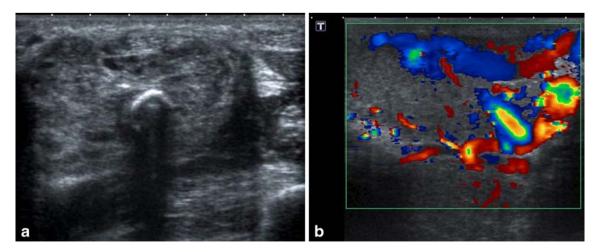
Nine-year-old boy with a congenital mass of the forearm. a US shows a heterogeneous echogenic mass containing phleboliths. b Colour Doppler performed at the age of 3 years shows numerous arteries and veins. Biopsy confirmed the diagnosis of NICH with GLUT1 negative
